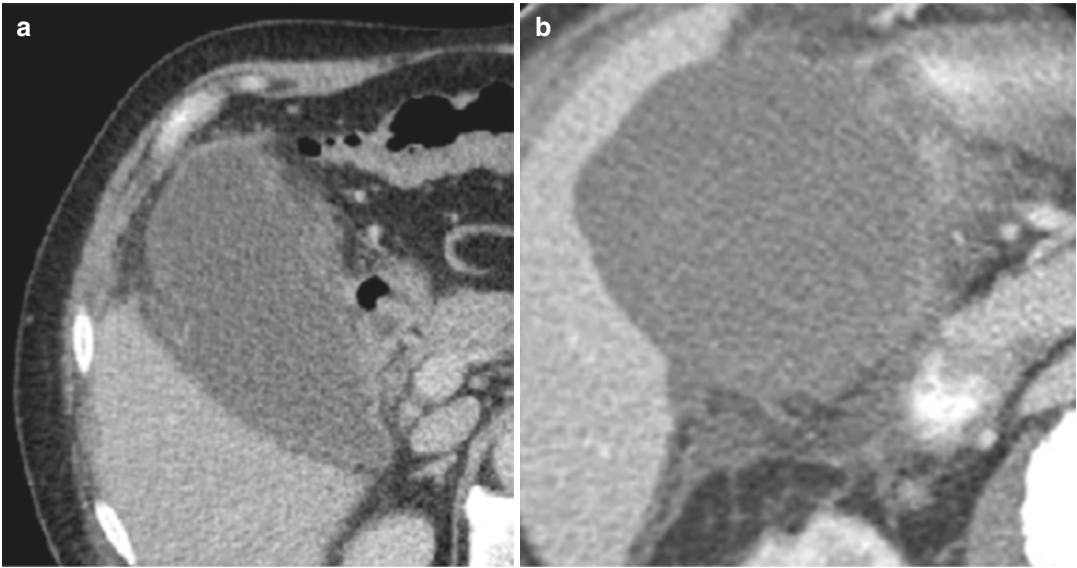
(a, b): CT scan Gangrenous cholecystitis
